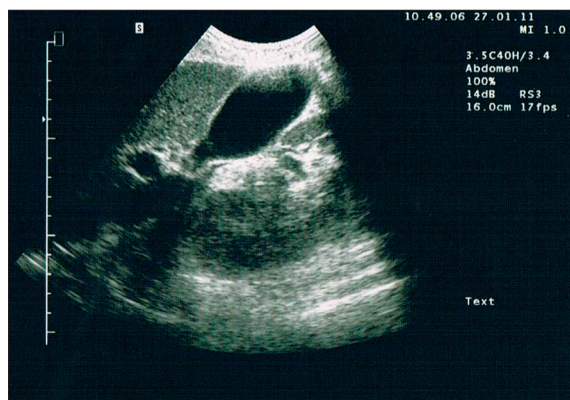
Abdominal ultrasonography performed after discharge, showing a normal gallbladder wall.
